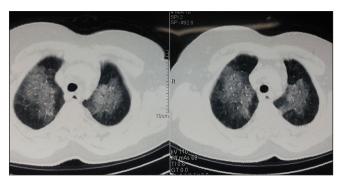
Computed tomography of chest showing bilateral infiltrates predominantly perihilar distribution
